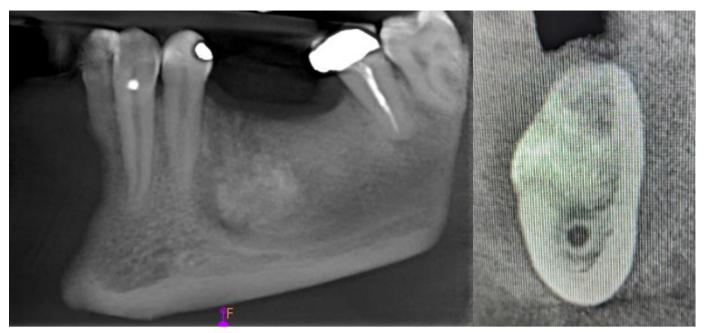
CBCT demonstrating graft fill following graft healing 7-months post treatment.
